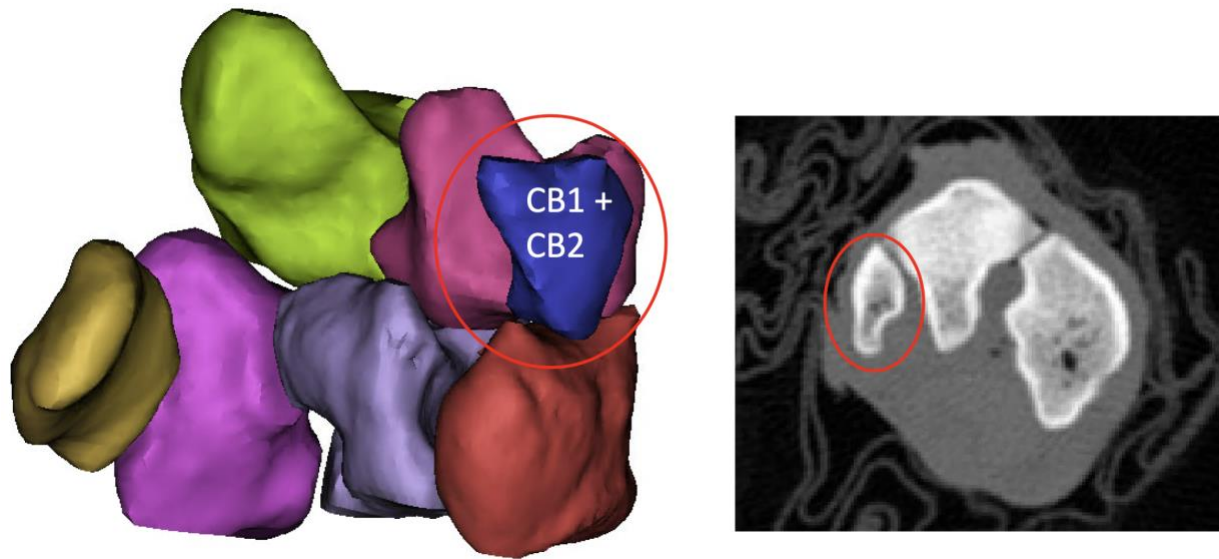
Left:* A three-dimensional surface generated from the S13 CT scan, with CB1) and CB2 (blue) appearing to be fused. *Right:* Axial view of the S13 CT scan, showing complete fusion of CB1 and CB2 (circled).
